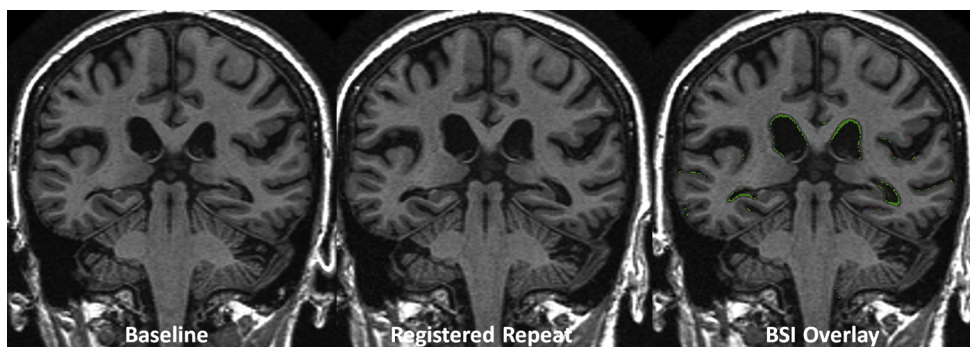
Boundary shift integral (BSI). Coronal, volumetric (three-dimensional or 3D) T1-weighted MRI scans from the same individual scanned at baseline and after an interval are shown. The second scan is aligned (spatially registered) to the first. Atrophy occurring between the two scans results in a shift at the brain/cerebrospinal fluid (CSF) interface (green overlay on third image). The BSI, the sum of the displacement of the brain/CSF boundary across the whole brain, provides a means of quantifying atrophy occurring between the two scans.
